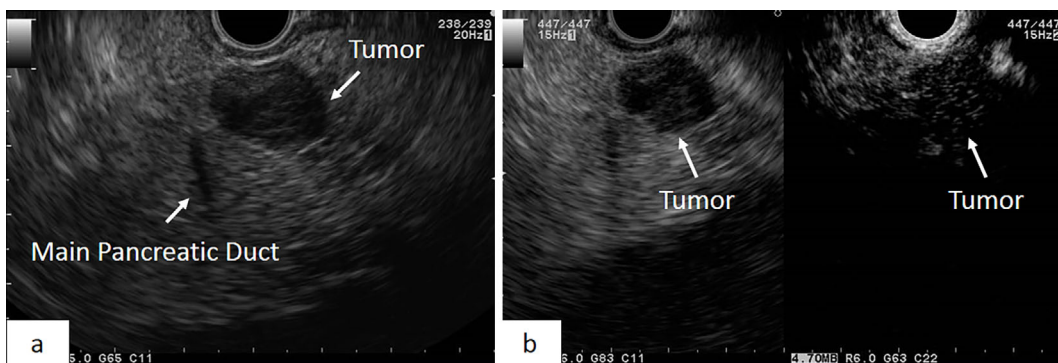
Endoscopic ultrasonography findings. (a) From the stomach, a hypoechoic tumor measuring 16×12.3 mm was found in the pancreatic body, with the pancreatic duct running close to it. There was no posterior echo enhancement or lateral shadows of the tumor. (b) Left: fundamental B-mode, right: contrast mode. The early and delayed phases are hypovascular compared with the surrounding pancreatic parenchyma.
